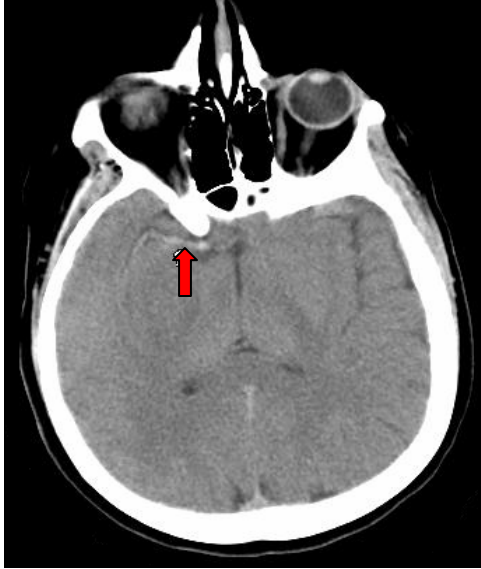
Noncontrast brain CT scan showing a tubular hyperdense structure consistent with acute middle cerebral thrombosis (arrow).
